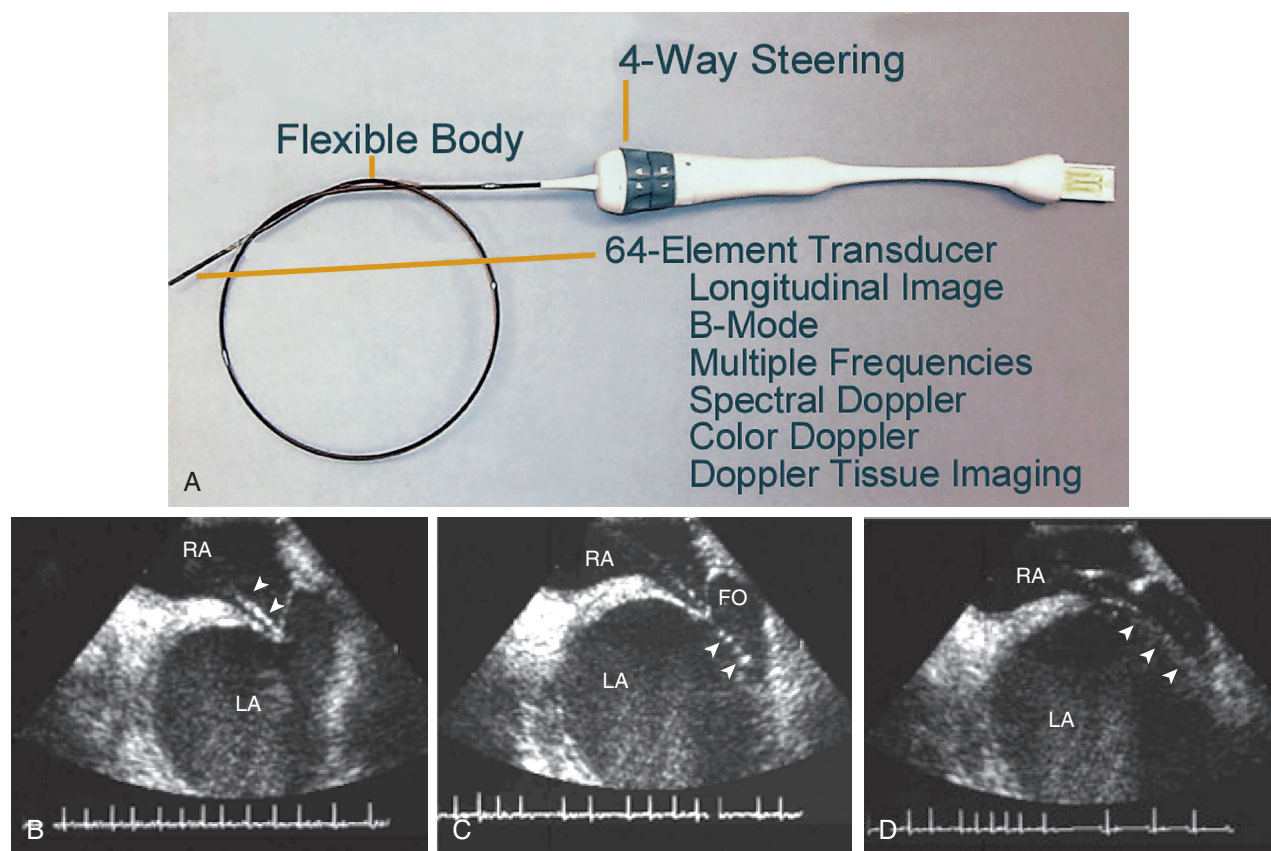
A, ICE disposable transducer (Acuson, Inc.) with a steering apparatus on the proximal end and a flexible body with a transducer on the distal tip of the catheter. B, Tenting of the membranous fossa by the dilator-needle assembly. The transseptal needle assembly (arrowheads) is advanced to indent the fossa membrane. C, Advancement of the transseptal needle across the membranous fossa. Here the needle (arrowheads) is seen near the posterosuperior left atrial wall. The membrane remains tented because the dilator has not yet crossed the septum. D, Passage of the dilator and sheath across the interatrial septum. The dilator and sheath assembly has now advanced into the left atrium, thereby releasing the tenting of the membranous fossa. FO = fossa ovalis; LA = left atrium; RA = right atrium. (From Johnson SB, Seward JB, Packer DL: Phased-array intracardiac echocardiography for guiding transseptal catheter placement: Utility and learning curve. *Pacing Clin Electrophysiol* 25:402, 2002.)
